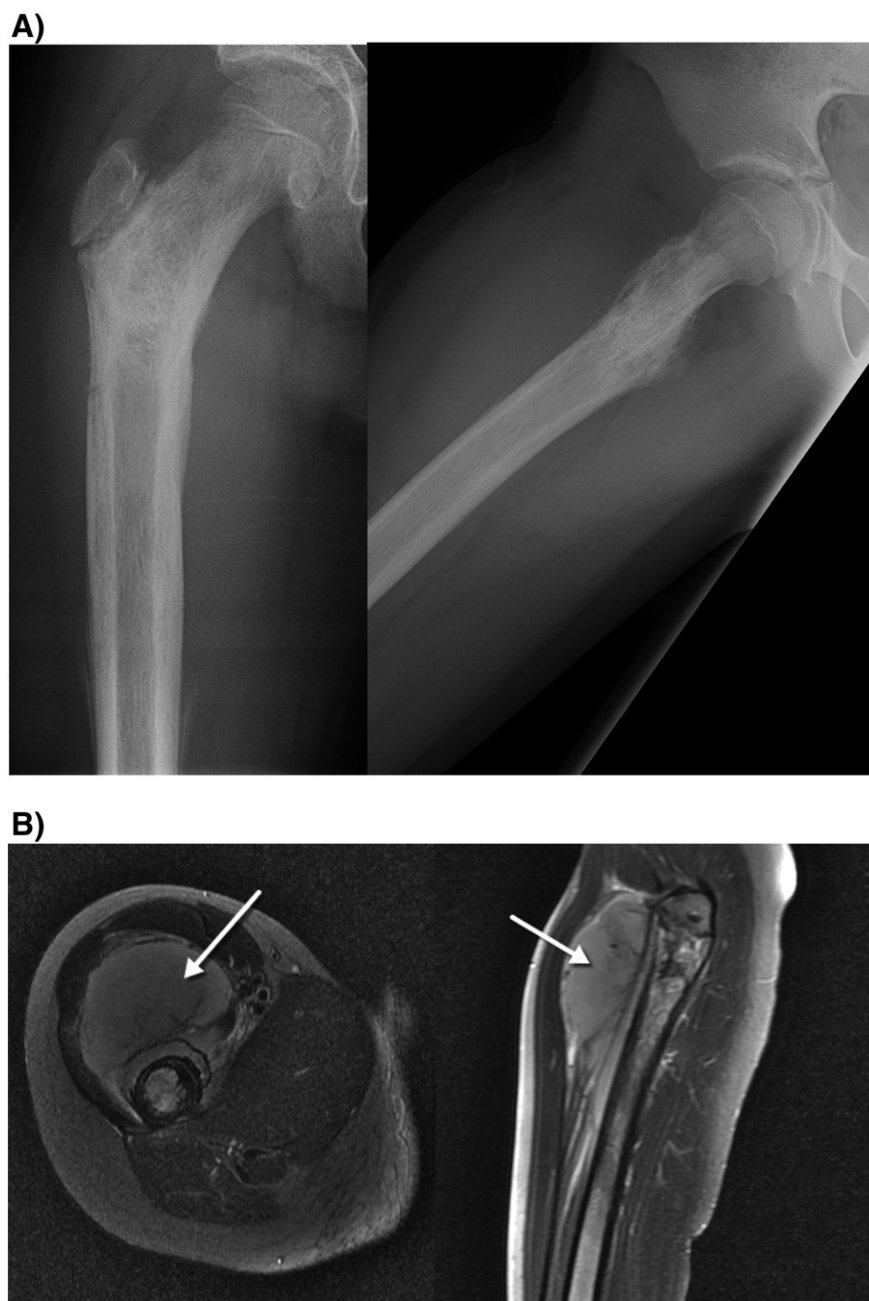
Ewing sarcoma in an adolescent with limp, radiographs, and corresponding MRI demonstrating Ewing sarcoma of the proximal femur, with a destructive pattern, mainly at the intertrochanteric and proximal shaft. Periosteal reaction is interrupted and aggressive. A large soft tissue mass is also present.
